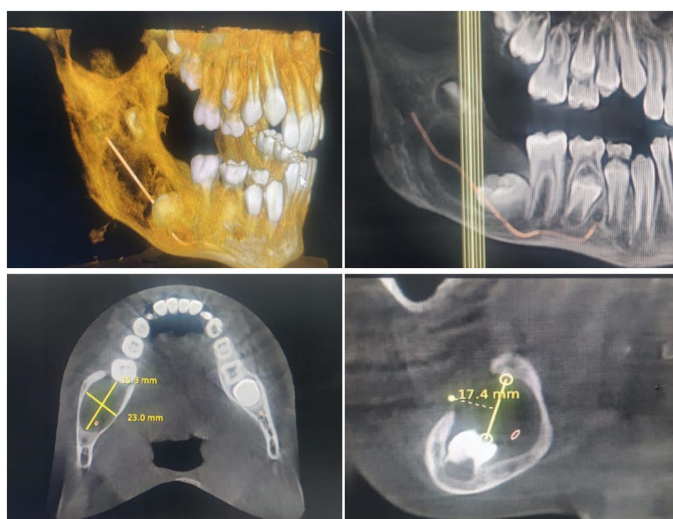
CBCT after 6 months of marsupialisation showing notable reduction in lesion volume.
